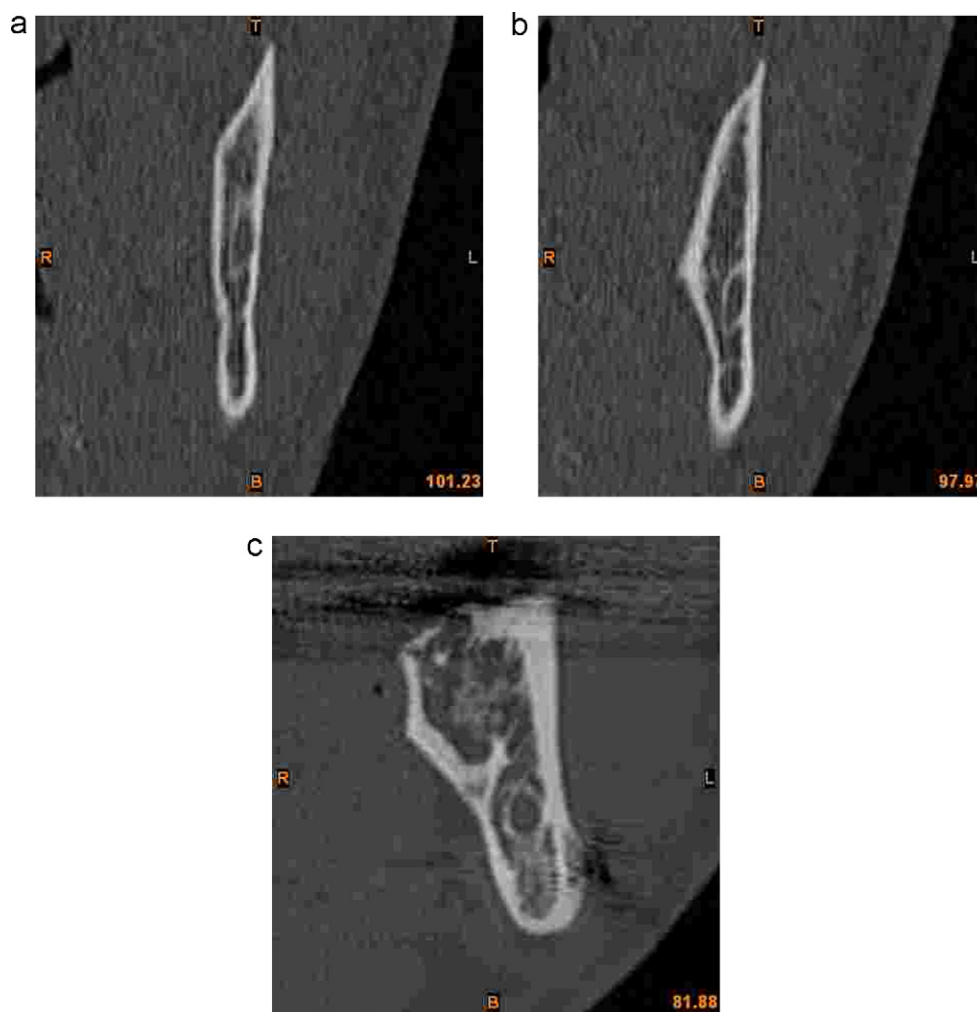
Coronal CT showing proximity only at the buccal cortex at positions (a) X1, (b) X2 and (c) X3.
